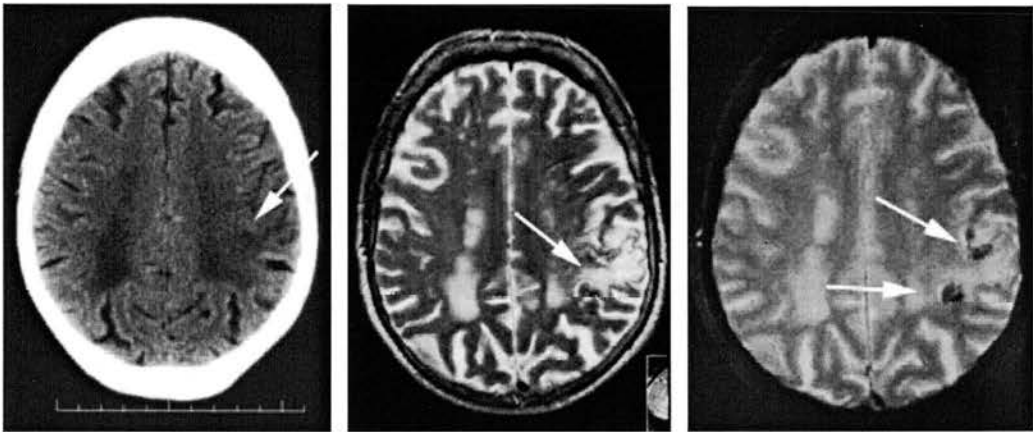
72 year old woman with 4 transient episodes of right facial numbness, one associated with right hand parasthesia. Scanned at 28 days. CT on left, gradient echo right.
